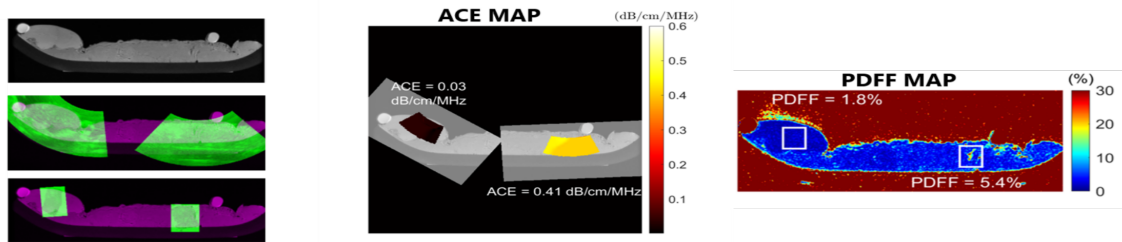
Left: Multimodal registration for an example placenta case: MRI PDFF image (top), ultrasound overlaid on MRI (middle), and pathology images overlaid on MRI (bottom). Middle: Ace map overlaid on the MRI. The mean ACE value for two regions-of-interest have been shown. Right: PDFF map showing mean PDFF for the corresponding regions-of-interest.
